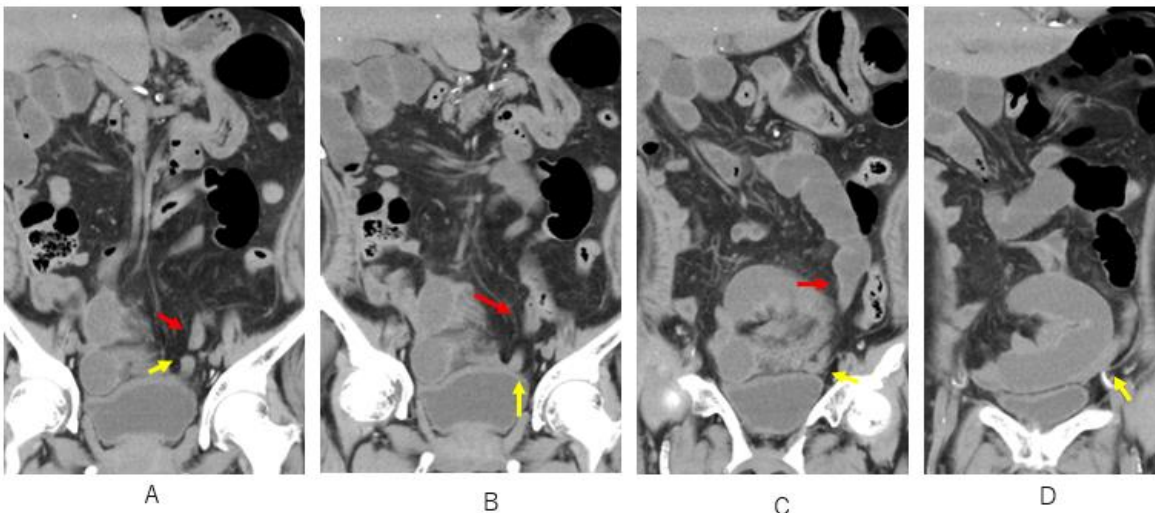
There is a double knot sign on coronal CT; red arrow indicates connection to oral-sided dilated bowel (A-C): another knot indicates connection to anal-sided constrictive bowel (A-D). Note that mesenteric edema heads to double knots (A, B).
